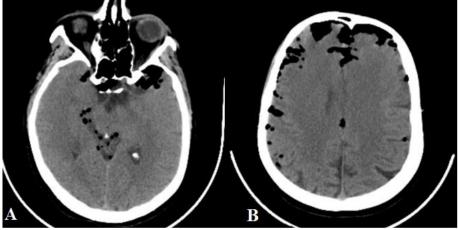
Post-operative axial cranial CT findings showing pneumocephalus.
